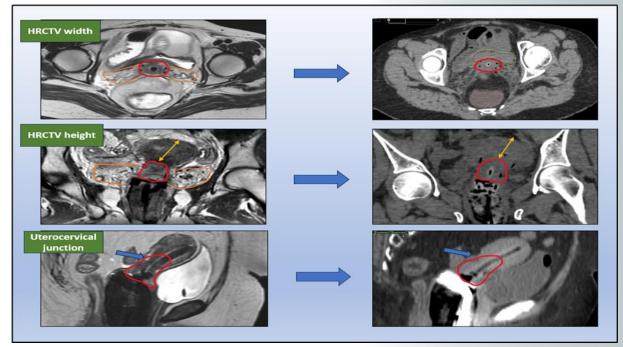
Using MRI information to estimate target width, height and tumour extent to contour on CT slices
